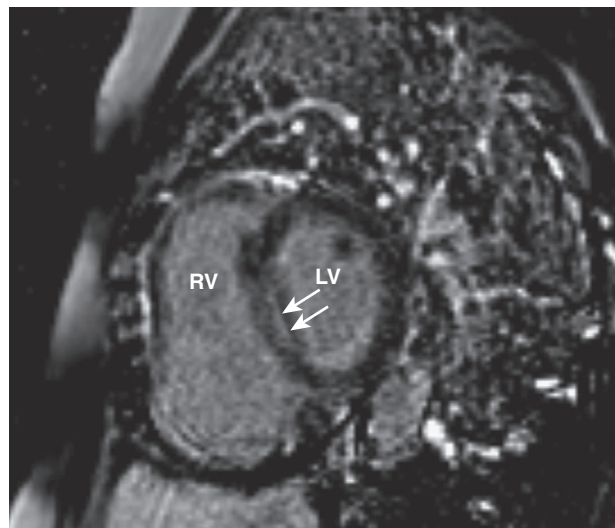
Sarcoidosis. Delayed enhancement magnetic resonance imaging in a patient with biopsy-proven pulmonary sarcoidosis demonstrating increased signal (*arrows*) in the interventricular septum suggestive of cardiac involvement. *LV*, Left ventricle; *RV*, right ventricle. (Courtesy Dr. Jean Jeudy.)
